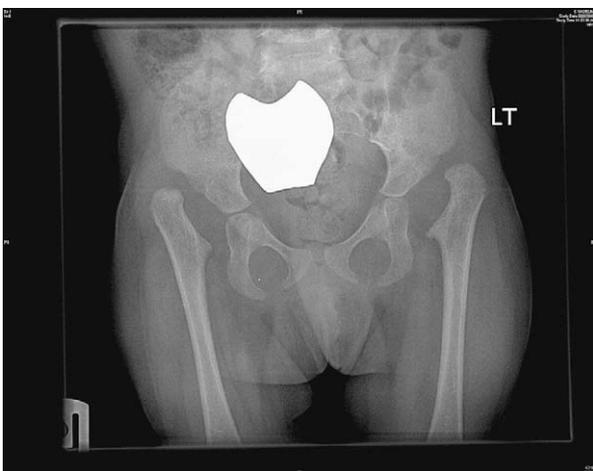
Radiograph of bilateral late presenting hip dislocations.
